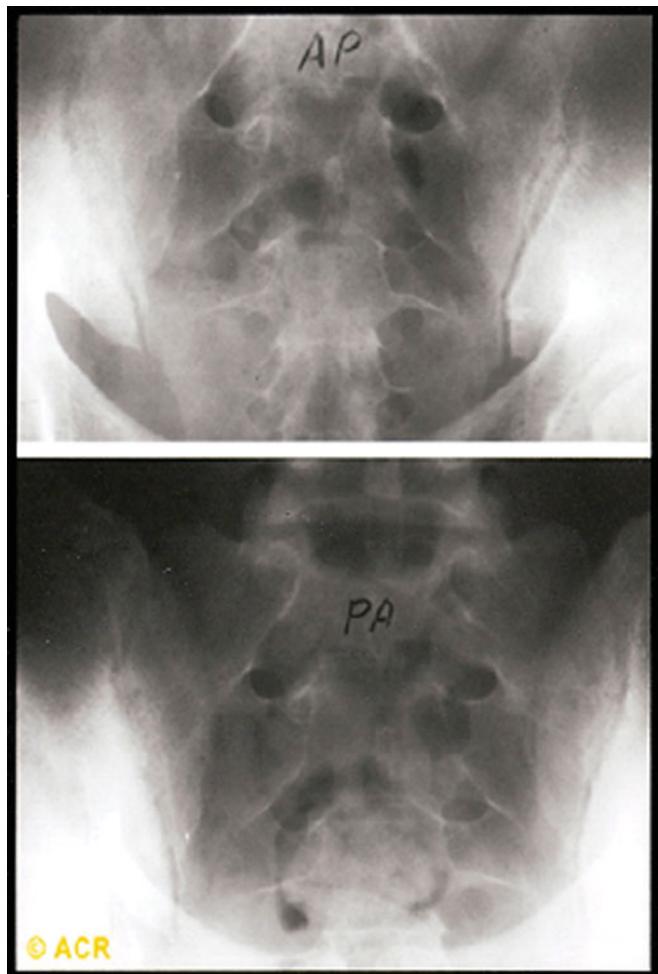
Reactive arthritis (REA); sacroiliitis: Sacroiliac joints are shown in Ferguson (top view) and posteroanterior projections (bottom). Moderate narrowing and sclerosis appear on adjacent margins of the middle third of the sacroiliac joint on the left; the sacroiliac joint on the right is relatively normal. Asymmetry is more common in reactive arthritis and psoriatic spondylitis than in idiopathic ankylosing spondylitis. (From Berens DL. Roentgen features of ankylosing spondylitis. *Clin Orthop Relat Res* 1971; 74: 20-33.)
